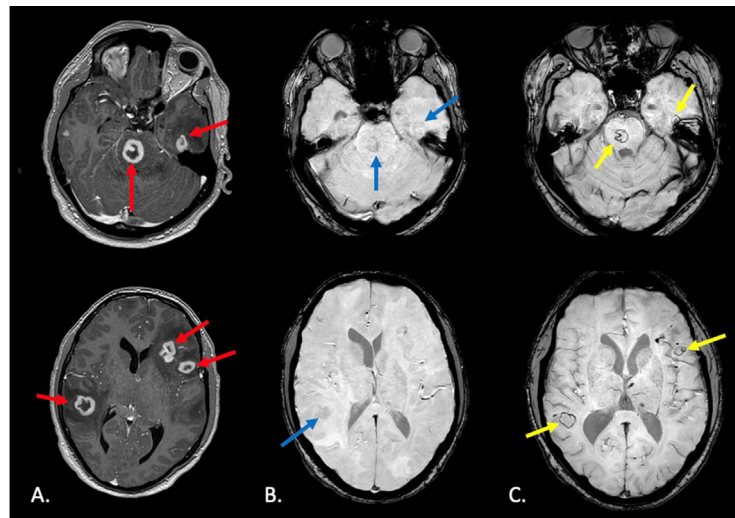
Column A. shows axial sections of a T1 weighted post-gadolinium MRI of the brain, revealing numerous enhancing PCNS-PTLD lesions, pre-treatment (red arrows). Column B. shows corresponding axial sections of a gradient echo MRI of the brain, revealing minimal punctate intratumoral susceptibility signal (ITSS) predominately within the brainstem lesion, pre-treatment (blue arrows). Column C. shows corresponding axial sections of a gradient echo MRI of the brain, revealing a peripheral pattern of intratumoral susceptibility signal (ITSS), post-treatment (yellow arrows).
